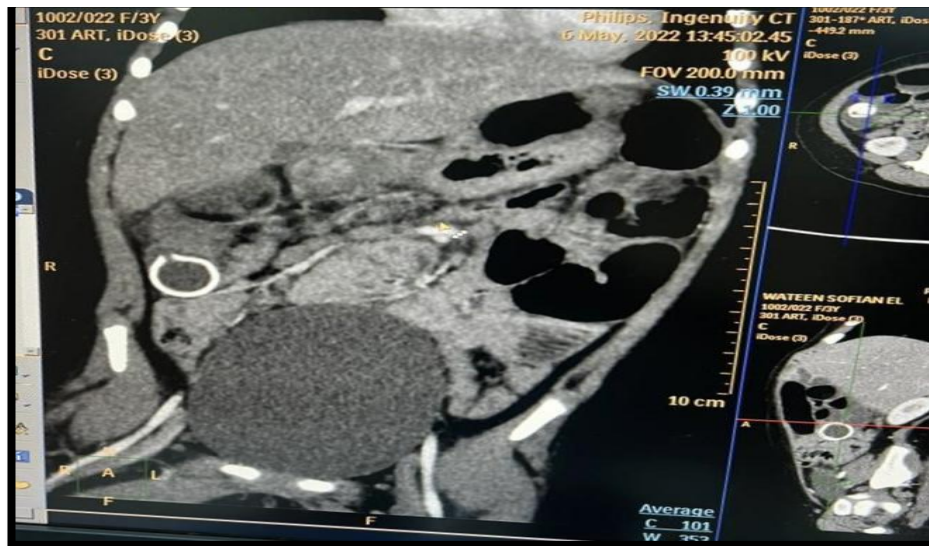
Ring Shape foreign body lodged at ICV in the CT scan of the abdomen
